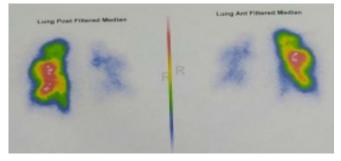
Perfusion scintigraphy shows in a patient persistent filling defects of the pulmonary arterial bed
